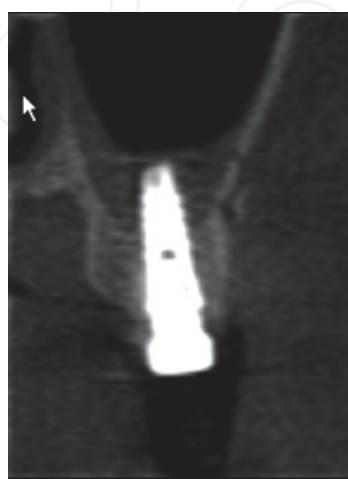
A postoperative cone-beam CT scans shows venous blood filled sinus.
